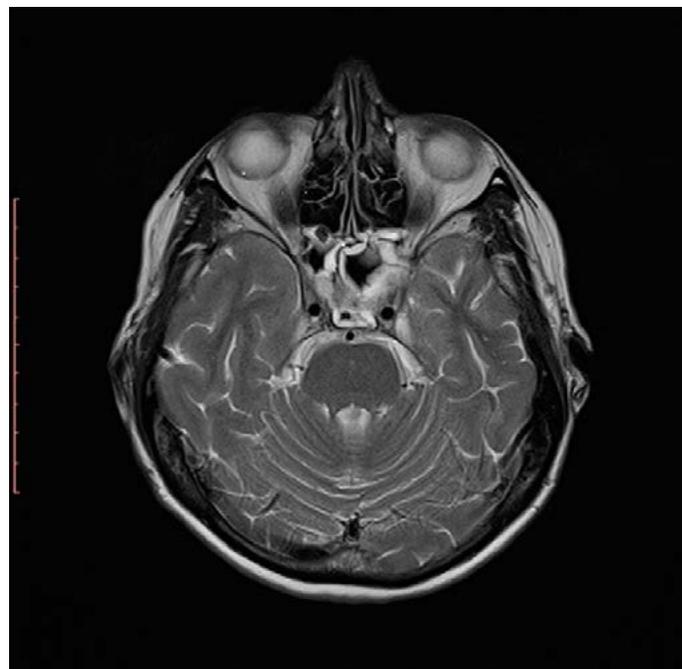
MRI scan with contrast enhancement, axial T2W image, performed 2 months after discharge. MRI shows mucosal thickening in both sphenoid sinuses, greater in the left than the right sinus and the presence of a fatty patch in the posterior part of sphenoid sinus.
